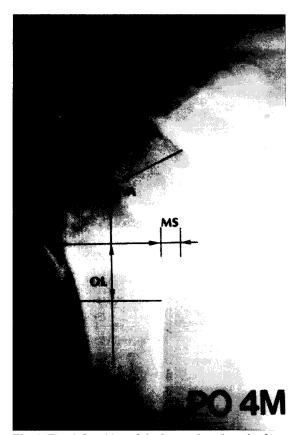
The deformities of the humeral neck at the fracture site were examined on anteroposterior radiographs of the proximal humerus to evaluate the medial shift(MS) of the distal fragment, varus angulation of the humeral neck(VA) and overlapping of the each fragment(OL).
